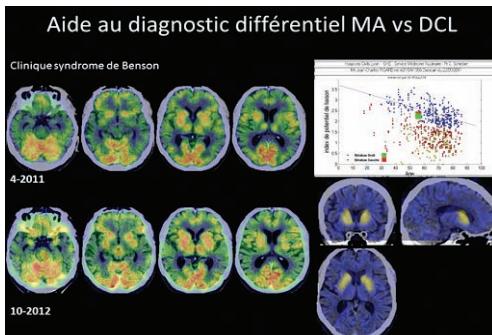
un examen hybride de perfusion cérébrale à l'HMPAO et DaTSCAN™ chez un patient présentant des signes en faveur d'une maladie d'Alzheimer atypique (syndrome de Benson) mais dont le diagnostic différentiel avec une maladie à corps de Lewy était difficile. L'examen DaTSCAN™ était strictement normal permettant de réduire le risque de MCL et la scintigraphie cérébrale (réalisée en 2011 et 2012) montre la stabilité des hypoperfusions étendues telle qu'on les rencontre dans la maladie d'Alzheimer (par exemple).
